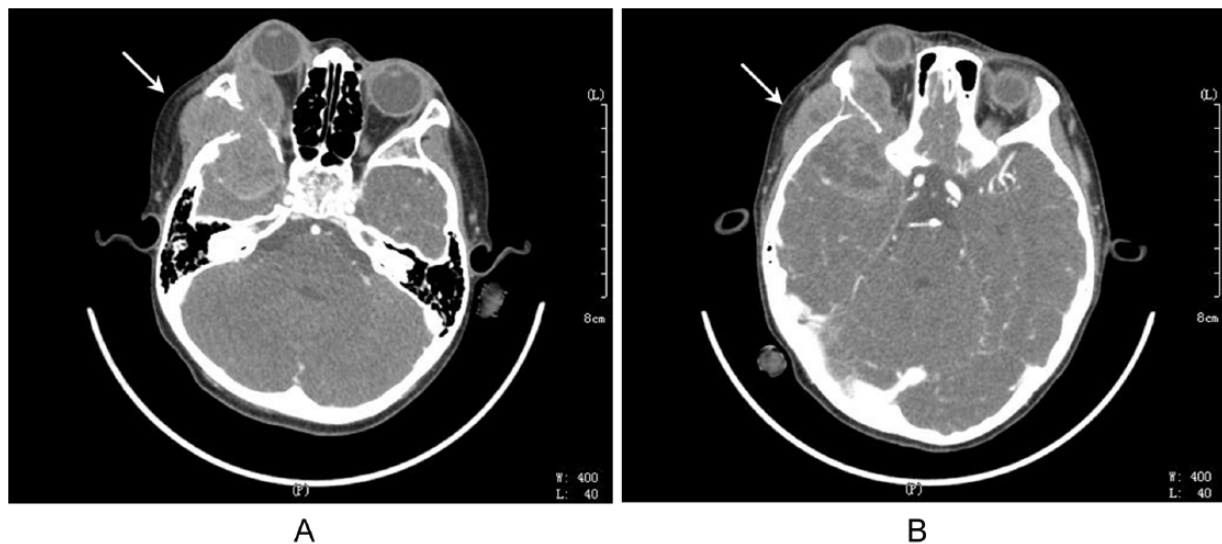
Computed tomographic scan of the orbit (layer A and layer B) demonstrates a heterogeneous soft-tissue mass in the right lateral orbital wall area.
